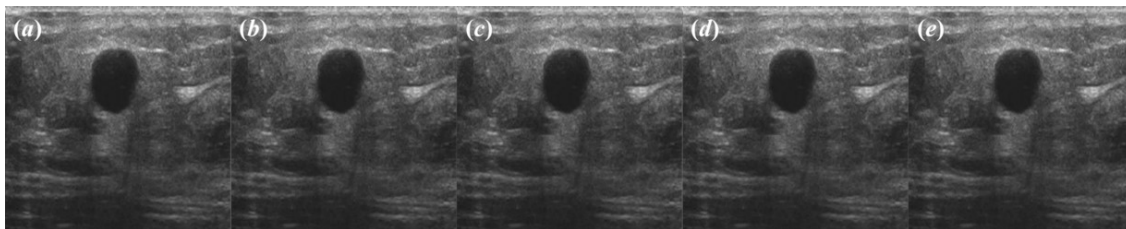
(a) Sample original ultrasound image of benign tumor and (b)-(e) corresponding images despeckled by (b) FI filter, (c) FB filter, (d) HFI filter and (e) HFB filter.
